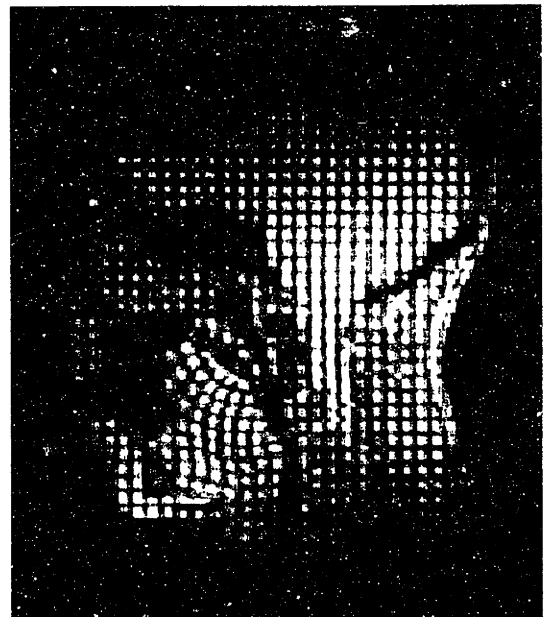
Tagging MRI for sagittal tongue bending
